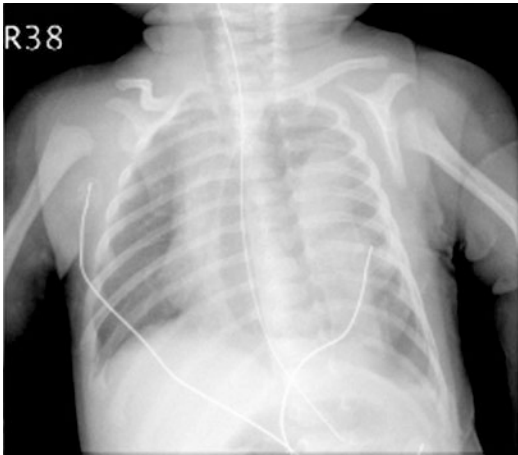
Chest X-ray of case 2 at the fourth day during the second hospitalization. The CXR reveals haziness of the left lung with pneumothorax and pleural effusion
